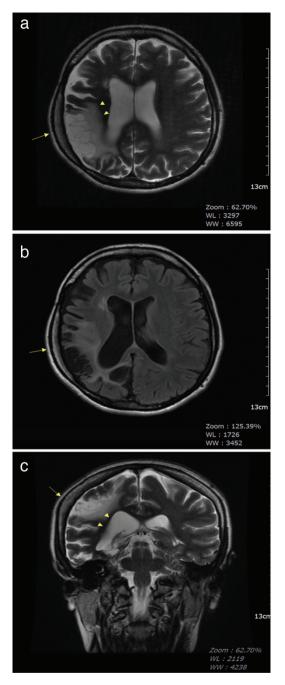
a) T2-W FSE and b) FLAIR supraventricular transverse images show that right cerebral hemiatrophy with enlarged sulcal space, right lateral ventricle, gliosis (arrow head), and also ipsilateral thickening of the calvarium (long arrow). c) Coronal T2W image shows right cerebral hemiatrophy with enlarged sulcal space and right lateral ventricle (arrow head), and also thickening of the calvarium (long arrow)
